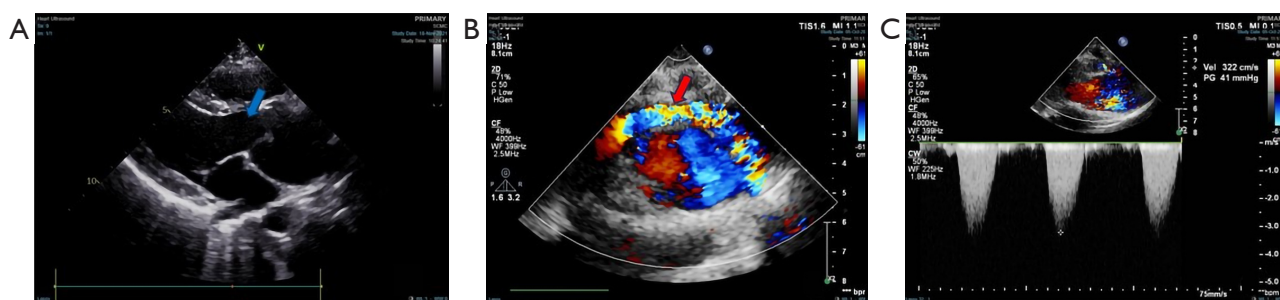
Evaluation of D-TGA vascular abnormalities using ultrasound color Doppler and blood flow. (A) Dilatation of aortic sinus (blue arrow); (B) mild pulmonary artery stenosis (red arrow); (C) moderate obstruction of the pulmonary artery (41 mmHg). D-TGA, dextro-transposition of the great arteries.
